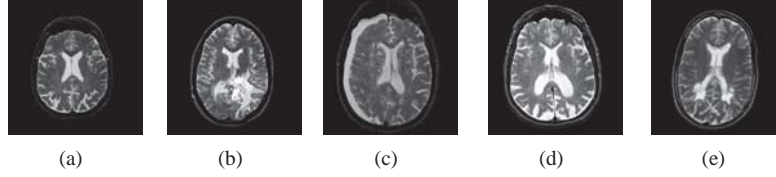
Sample of brain MR images with (a) Normal brain, (b) brain tumor, (c) stroke, (d) degenerative disease, (e) infectious disease
